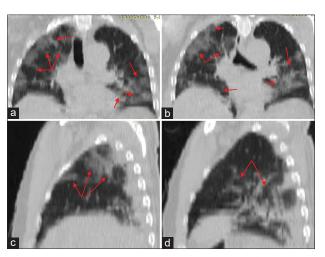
Chest computed tomography (CT) images of a 64-year-old man with asymptomatic symptom for coronavirus disease 2019. Chest CT with different planes, coronal plane (a and b) reconstruction shows bilateral multifocal ground-glass opacities (Red arrows) and sagittal plane (c and d) images show multiple patchy and bilateral areas of ground-glass opacities with a posterior predominance (Red arrows).
